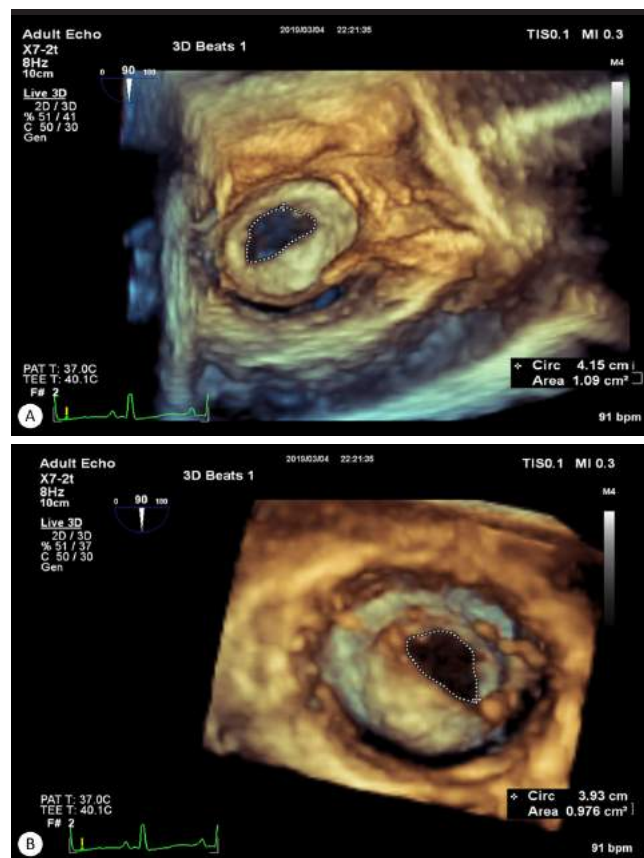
Three-dimensional transesophageal echocardiography before percutaneous transvenous mitral commissurotomy, showing severe mitral stenosis
